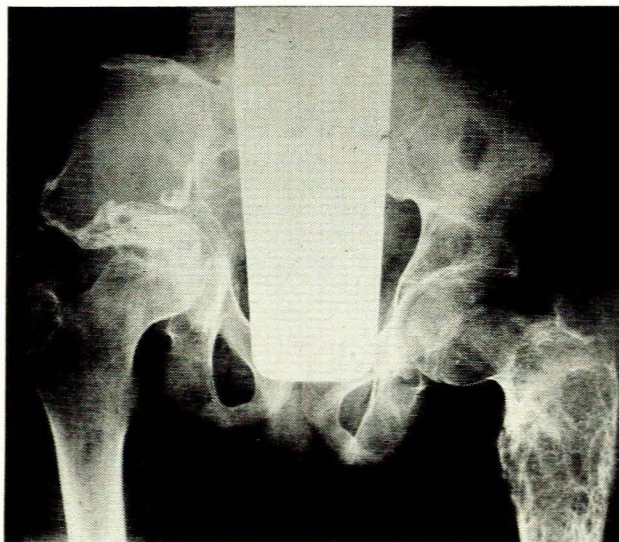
X-ray film of pelvis showing a large multicyclic osteolytic lesion involving the intertrochanteric region and upper third of the left femur. The right iliac bone is severely involved and the right acetabulum protrudes inwards.
